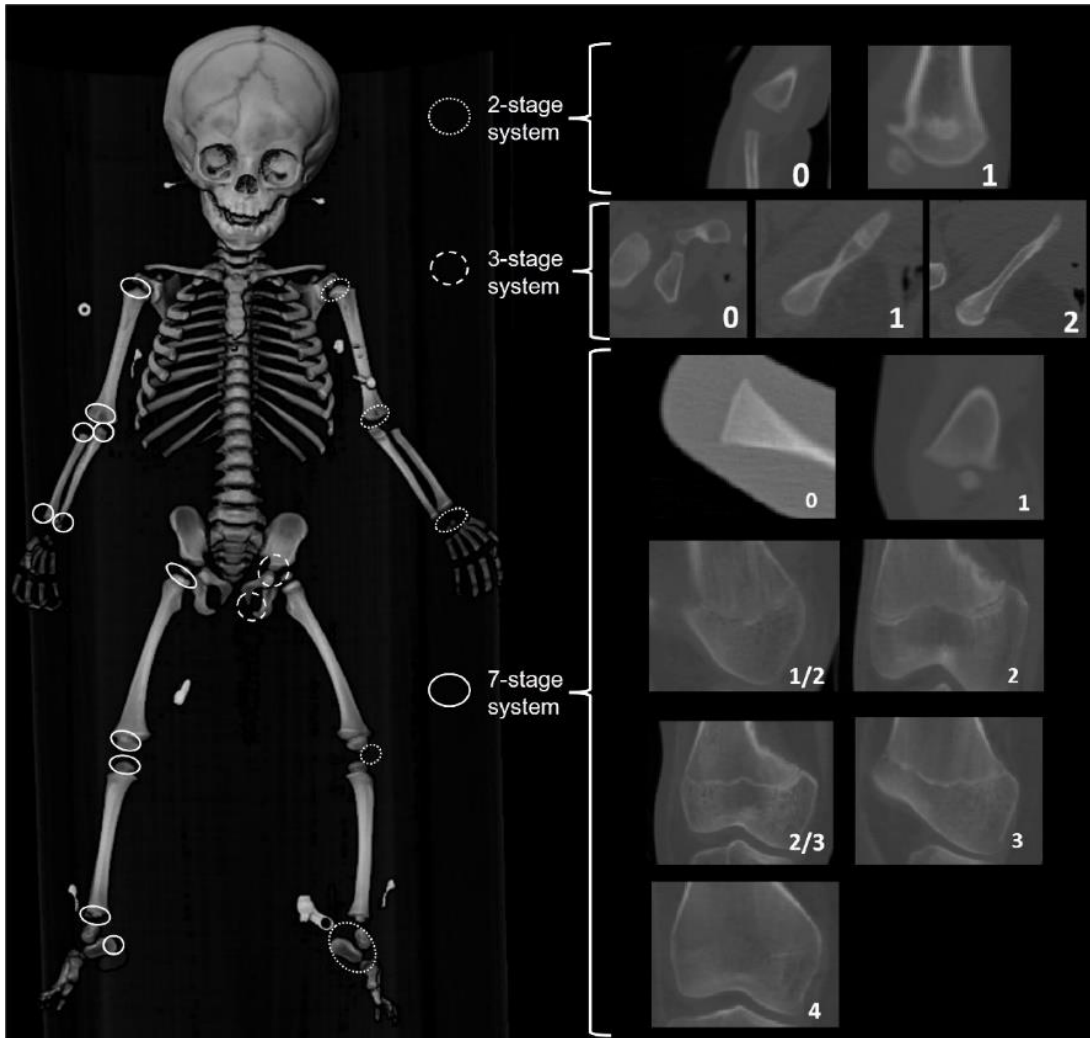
Sites for which ossification and epiphyseal fusion were scored following one of three staging systems developed for CT scans. Image taken from Stull et al.(2022).
